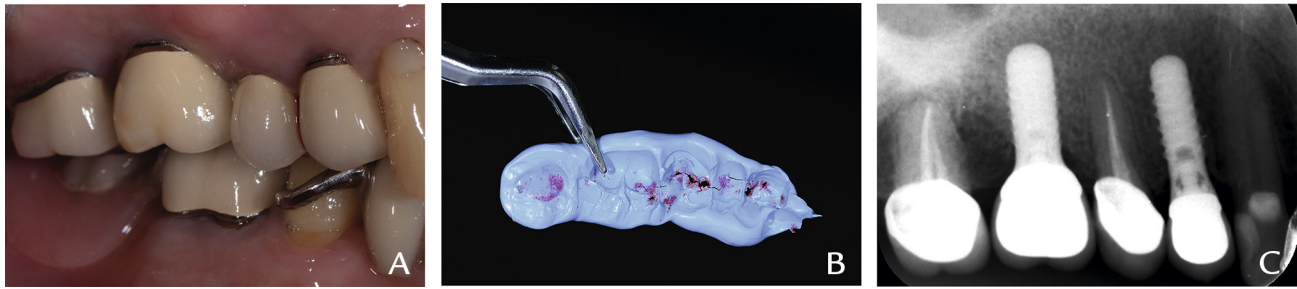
Normal occlusal contact maintained at 7-year recall. A, Buccal view. B, Silicone occlusal registration. C, Periapical radiograph.
